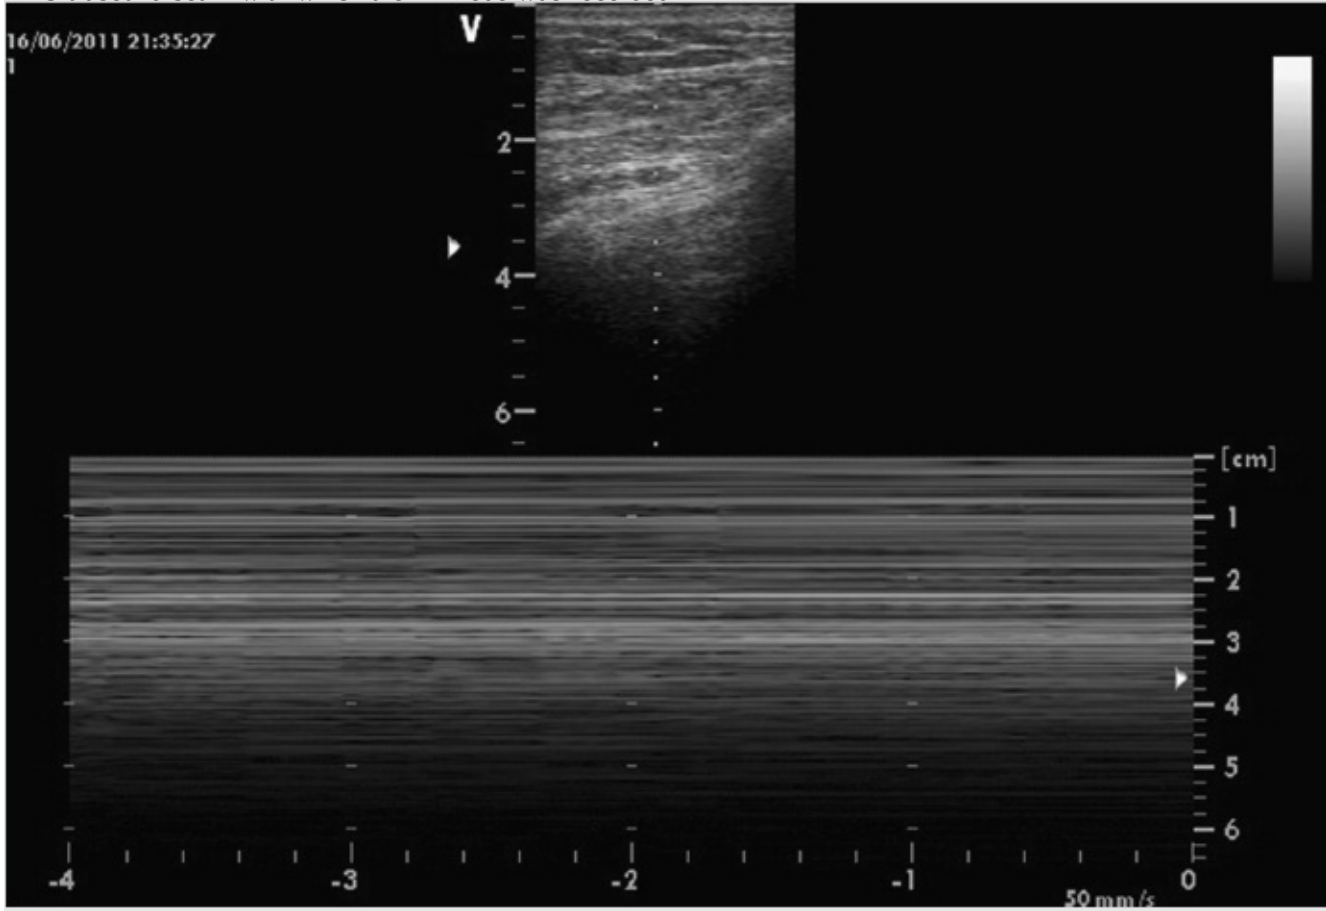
Intact pleura in M-mode. a Small image at top: Pleura in B-mode indicating the ultrasound beam in which the M-mode was recorded.
